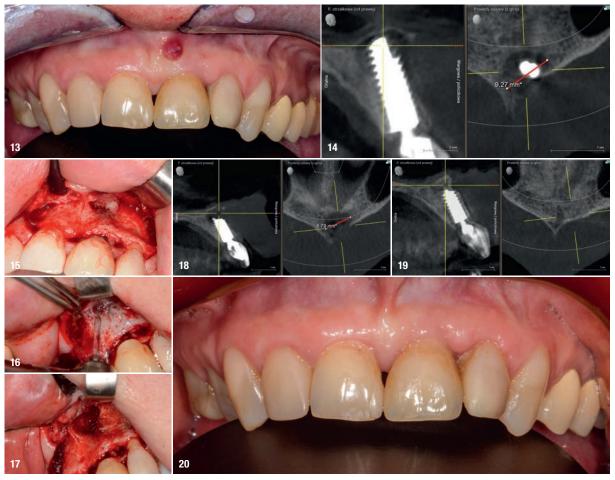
Initial situation. Visible fistula one year after loading. Fig. 14: Bone defect of 9.27 mm in diameter. Fig. 15: Flap elevation. Fig. 16: Granulation tissue removal with Er:YAG. Fig. 17: Implant resection. Fig. 18: CBCT scan on the day of surgery. No bone augmentation. Fig. 19: CBCT scan 1.5 years post-op. Visible bone regeneration. Fig. 20: Situation 1.5 years post-op. No sign of inflammation.
